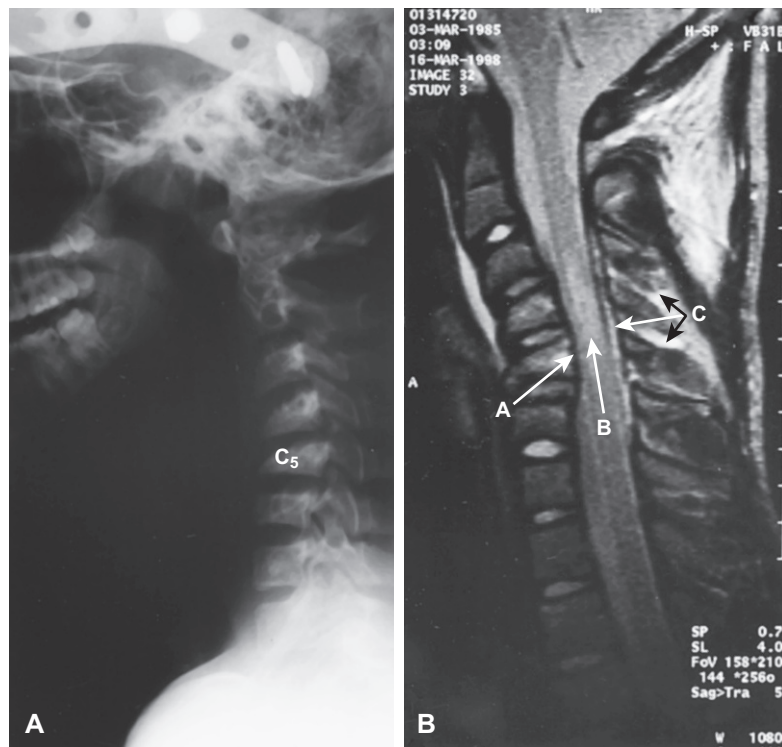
A, Lateral cervical spine radiograph of a patient with a flexion injury involving C5 shows malaligned posterior vertebral body lines. B, T2-weighted sagittal magnetic resonance image of the same patient showing probable injury to the posterior longitudinal ligament (A), an increased signal within the spinal cord (B) consistent with spinal cord injury, and a hyperintense signal involving the posterior ligamentous complex (C).
